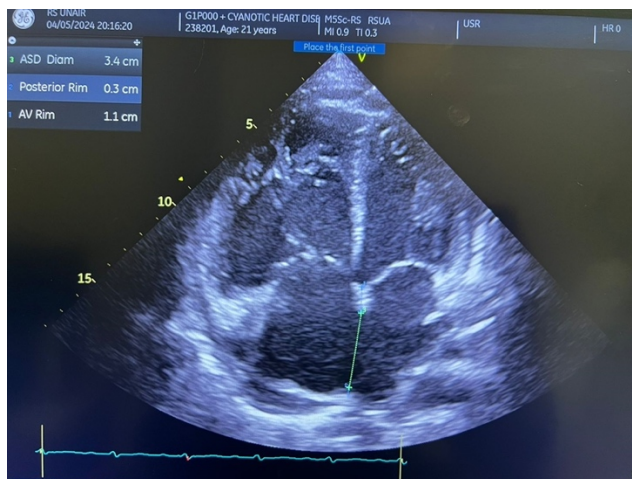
Echocardiograph
